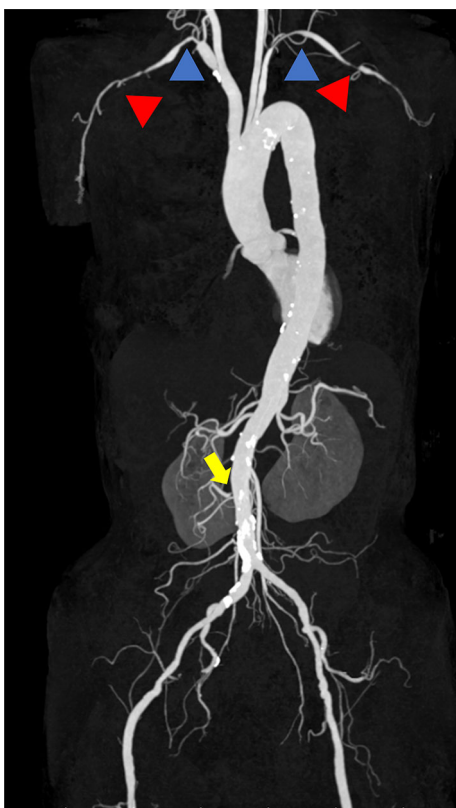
Three-dimensional reconstruction of the great arteries by computed tomography demonstrates stenoses in both the mid-subclavian arteries (blue arrowheads) and total long occlusion from the axillary to brachial arteries (red arrowheads) in both arms, without any significant stenosis of the thoracoabdominal aorta. Focal ostial stenosis of the right renal artery (yellow arrow) is evident.
